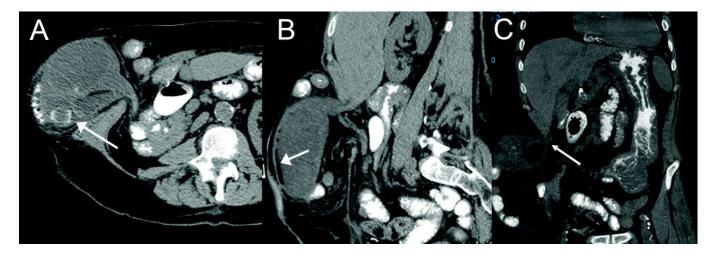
76 year-old man with gallbladder torsion in a parastomal hernia. Findings: Markedly distended and thick-walled gallbladder with gallstones, intramural and intraluminal gas (arrows) in a right lower quadrant parastomal hernia. The gallbladder neck is elongated and deformed; however, the twist is not clearly appreciated due to lack of intravenous contrast. Technique: Reconstructed axial (a), sagittal (b) and coronal (c) unenhanced CT with oral contrast, mAs 181, kV 120, slice thickness 5 mm.
